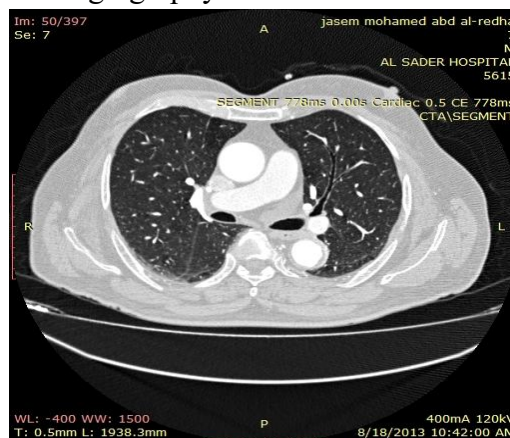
Bronchiectatic changes incidentally found in 50 years old woman who was referred for coronary CT angiography for evaluation of chest pain and dyspnea .
